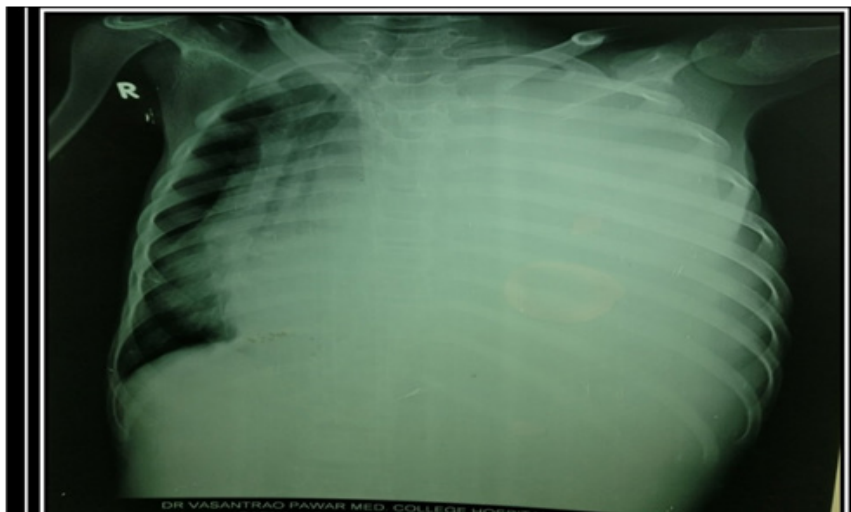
Pre procedure Xray-Chest PA view.
